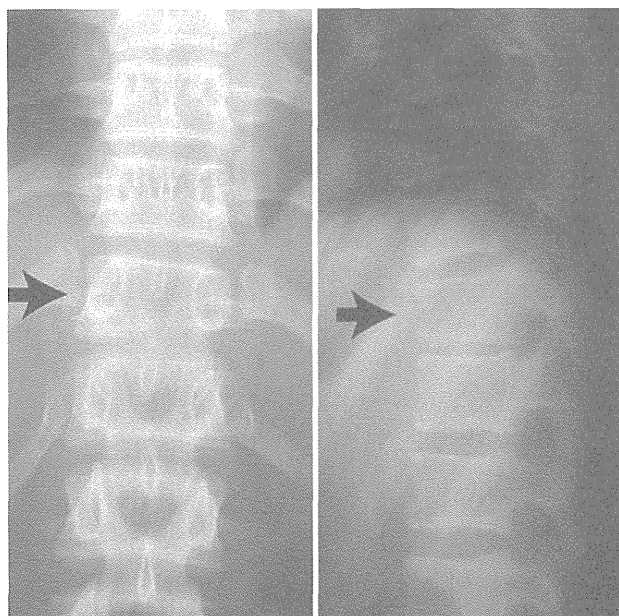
Plain radiographs showing a compression fracture of T-11 (arrows).
